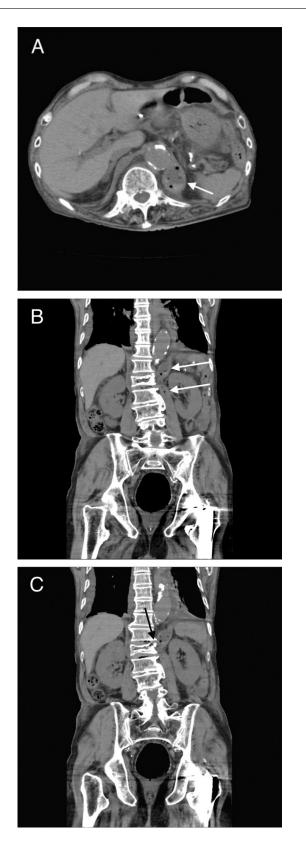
(A), (B) Axial and coronal CT images demonstrating low-density lesions with air in the left crus of the diaphragm and left psoas muscle (white arrows). (C) Continuity is suspected between lesions and the L1 body (black arrow).
